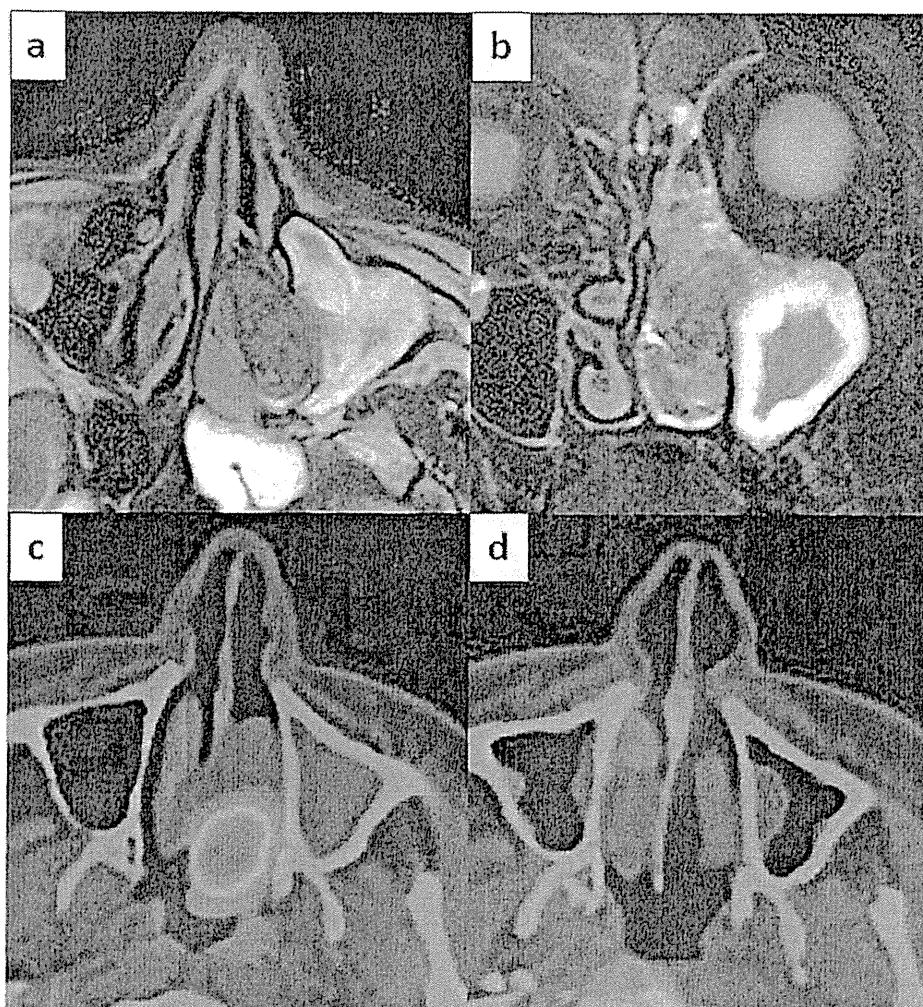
Images before and after proton beam therapy (PBT). *a*: Initial facial Magnetic resonance imaging (MRI), axial slice. *b*: Initial facial MRI, coronal slice. An irregular mass in the left nasal cavity, 40×32×20 mm, extending to the ethmoid sinus, is shown. *c*: Pre-treatment positron emission tomography (PET) showed significant fluorodeoxyglucose accumulation (FDG) with a maximum standardized uptake value of 13.1. *d*: PET after PBT showed loss of FDG accumulation in the lesion.
